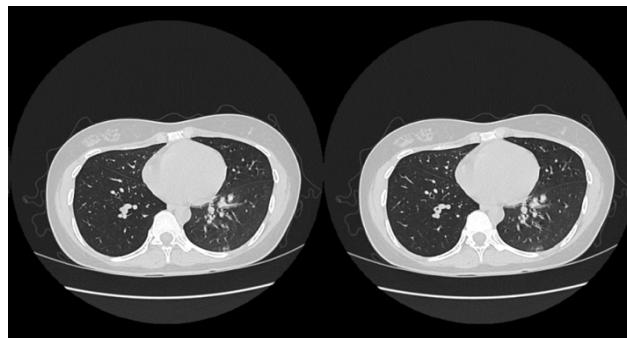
Thorax CT-Scan showed consolidation with fibrosis and tree in bud opacities
